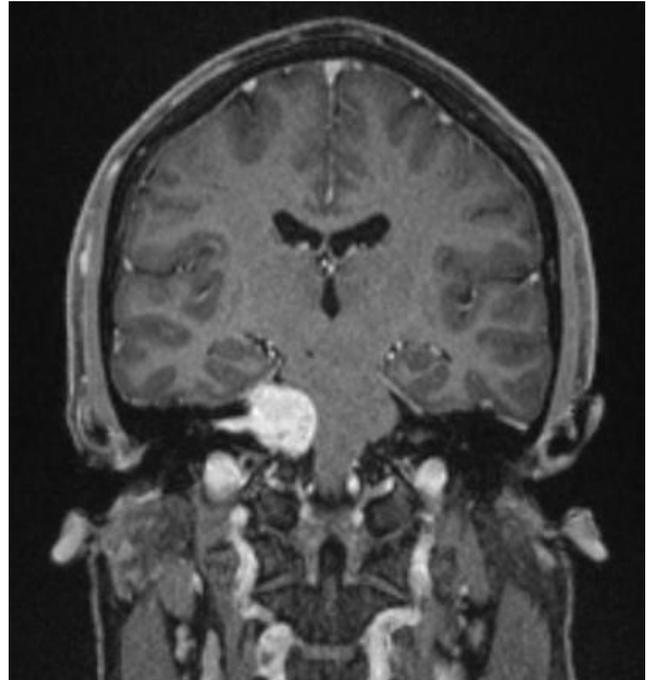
Coronal Gadolinium enhanced MR image shows a rounded enhancing Acoustic neuroma in right CP angle extending into right internal acoustic meatus.
